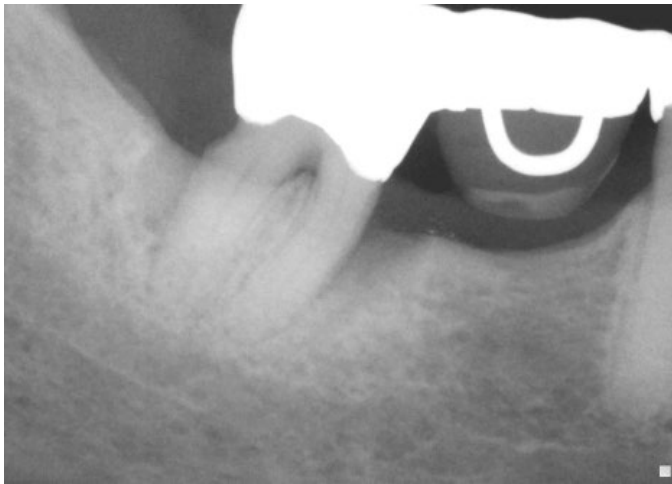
(A) This X-ray shows significant mesial and distal bone loss in an 82-year-old woman.
